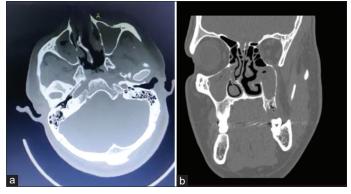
Pre-operative computed tomography picture of the patient
